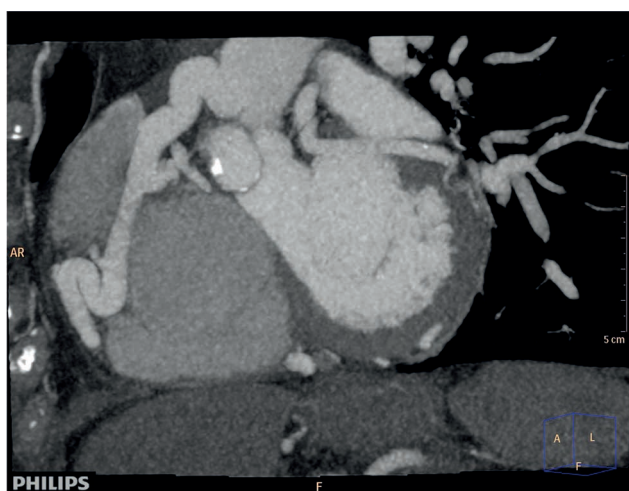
Cardiac computed tomography showing large, tortuous right coronary artery originating from the main pulmonary artery.
